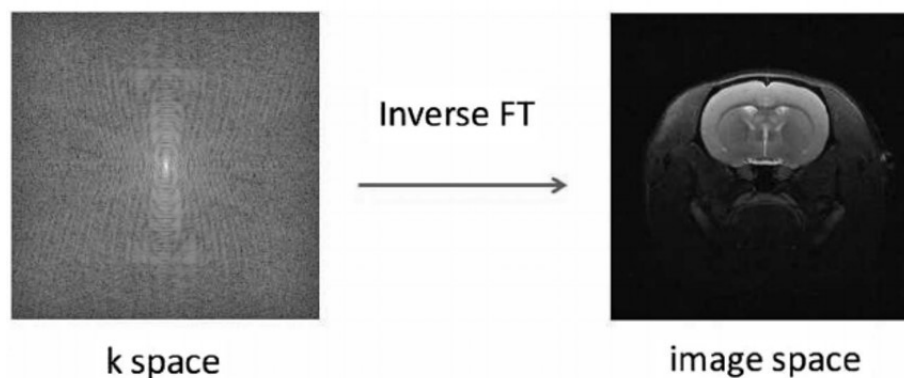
MRI generation from k-space MRI Modalities
